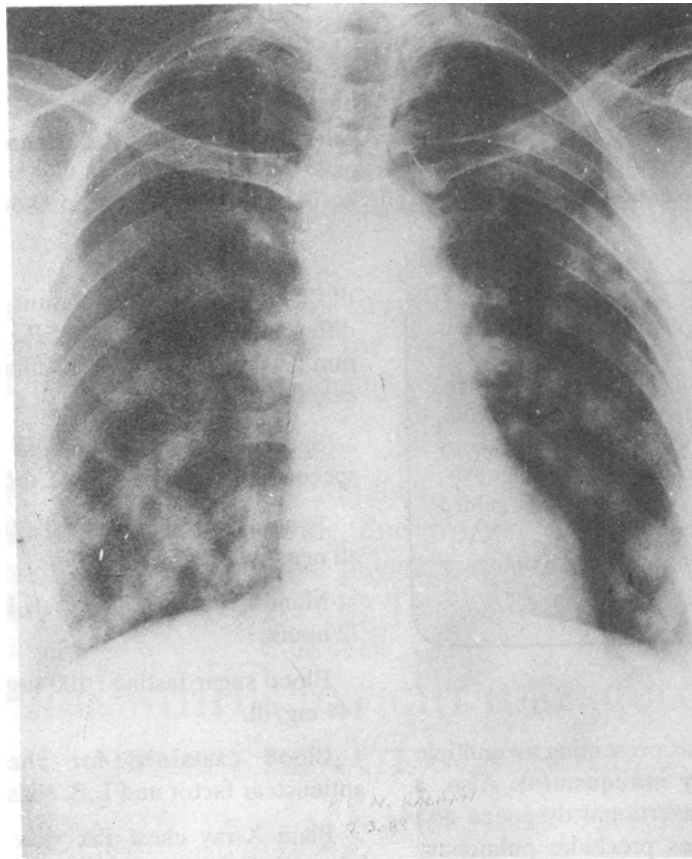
Plain X-ray Chest PA view at initial presentation.
